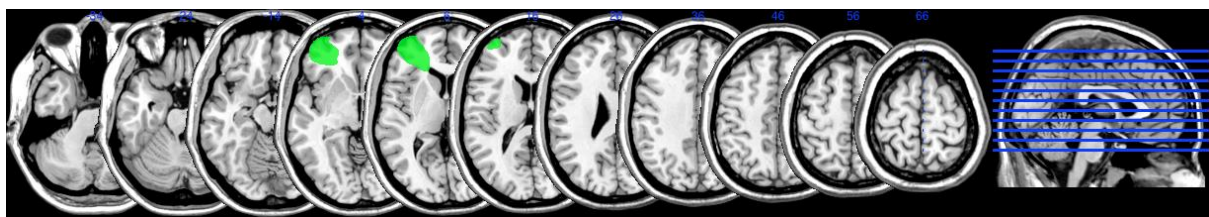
MRI scan of patient BP
